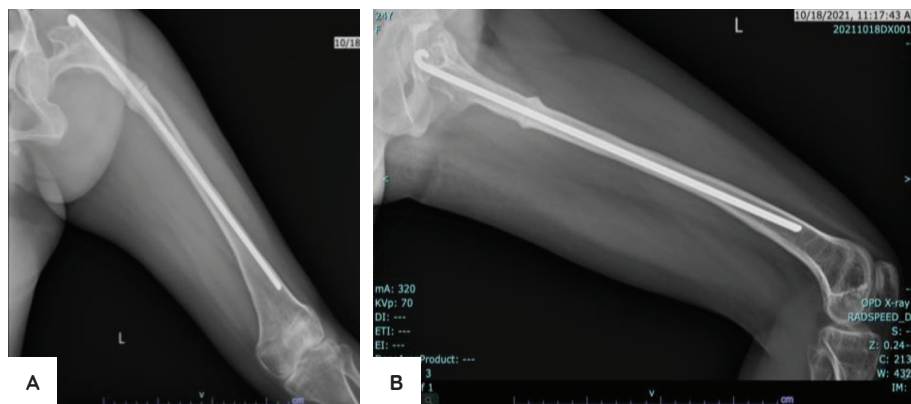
Left femur x-rays (with fixation). Anteroposterior x-ray of the left femur showing healed pathologic fracture and adequately inserted implant (A). Lateral x-ray of the left femur showing healed pathologic fracture and adequately inserted implant (B).
